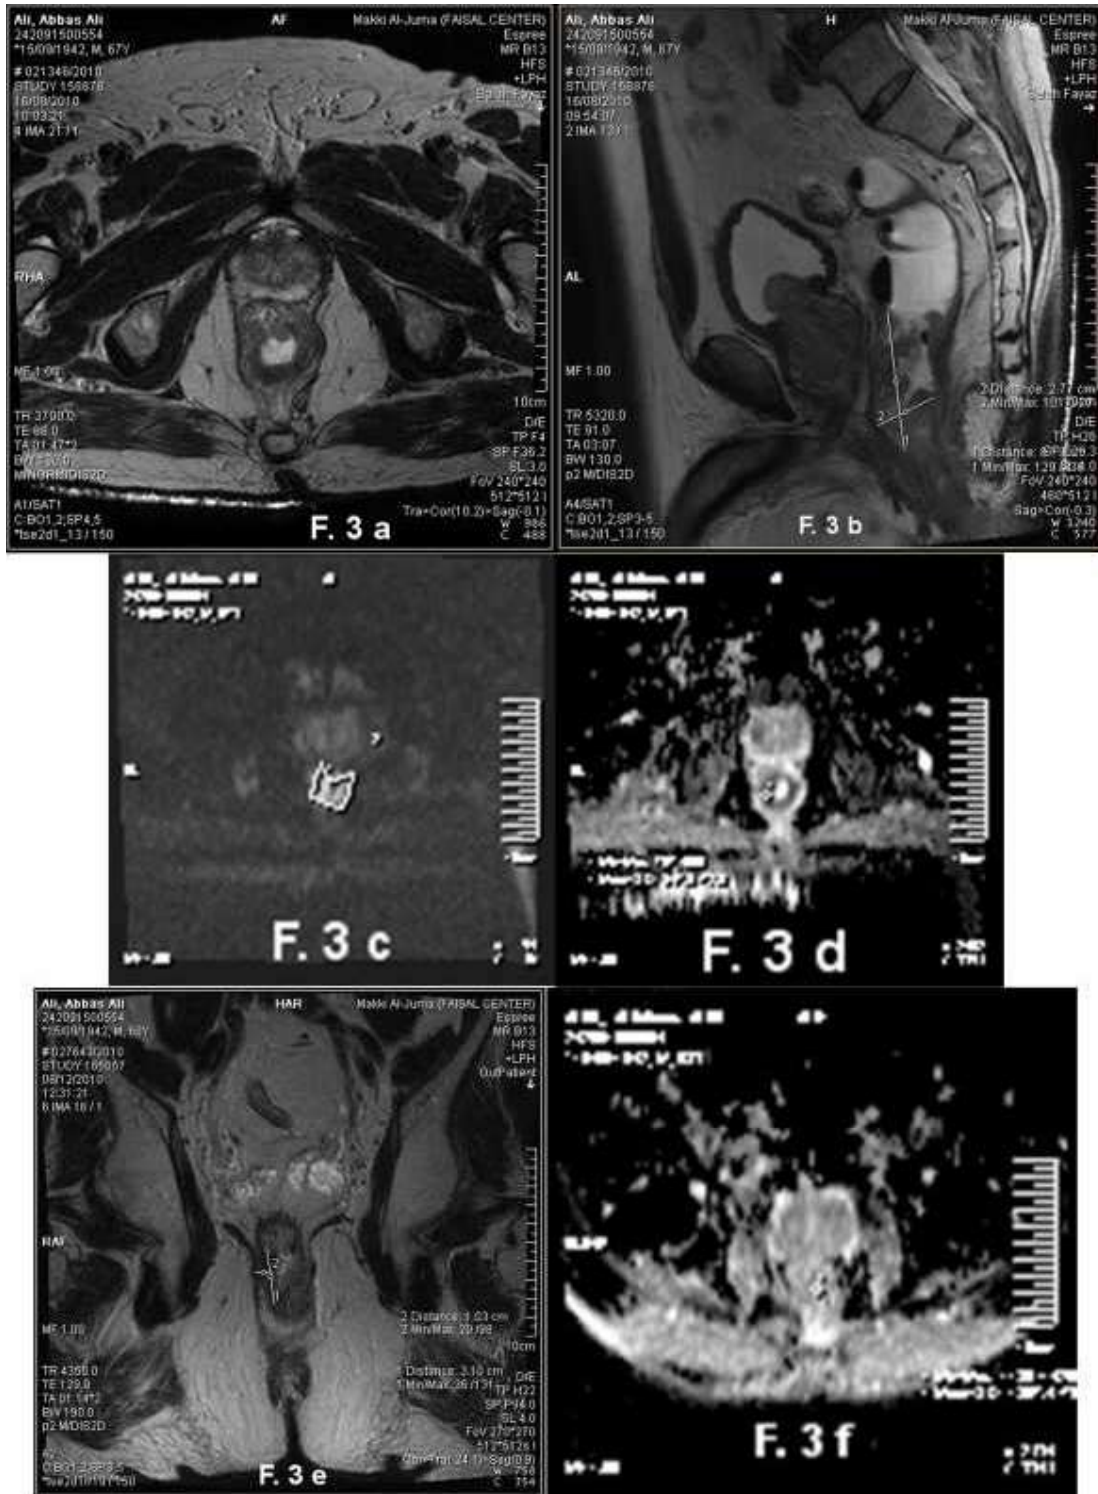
A 46 –year old male patient presented by bleeding per-rectum. (A) Axial T2WI HR Pre CRT showed circumferential mural mass.(B) SagittalT2WIpreCRT showed intermediate signal of a mass measures 6.5x27cm.(C) DWI(1000 b value) shows bright signal at tumour site.(D) ADC shows black signal at tumour site.(E) Coronal HRT2WI post CRT showed decrease in tumour size.(F) ADC=1.4x10 mm/sec, showed decrease in black signal
